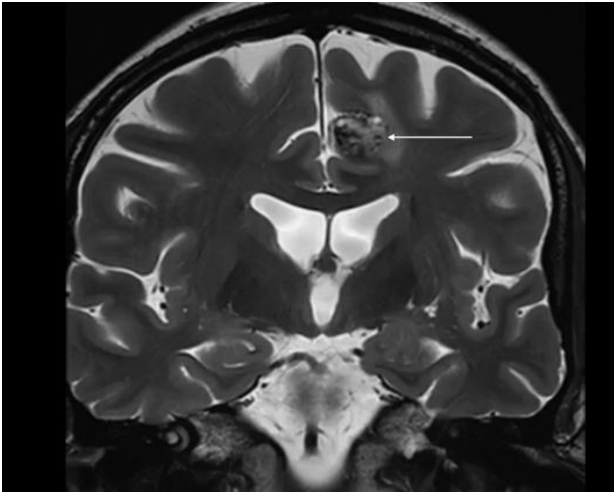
MRI brain (T2-weighted axial) showing Zabramski type II cerebral cavernous malformation in right frontal lobe.
